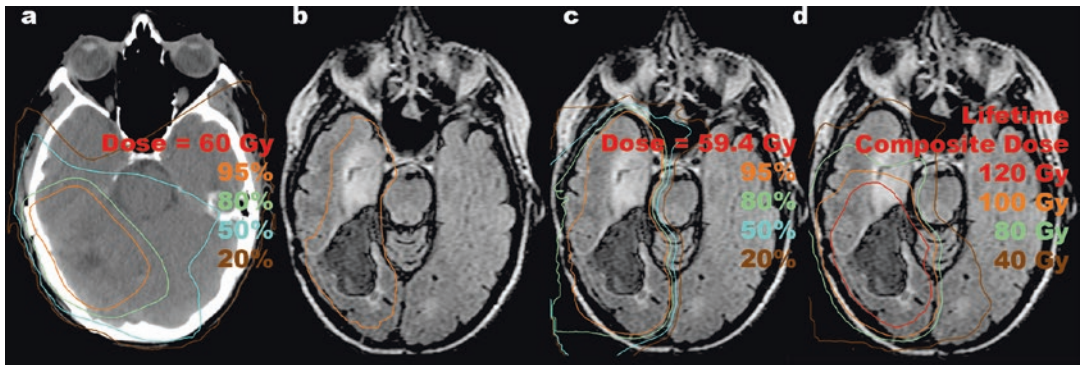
A 48-year-old woman was reirradiated for a recurrent glioma. She had a history of a complete resection of right posterior temporal anaplastic astrocytoma (grade III) and received adjuvant radiation therapy to 60 Gy in 30 fractions (a) without chemotherapy. Seven years later she developed episodes of confusion prompting MRI scan that revealed local recurrence of non-enhancing tumor with progression of FLAIR abnormality into the anterior ipsilateral temporal lobe highly suspicious for tumor. She underwent radical subtotal resection guided by functional MRI, confirming recurrent grade III astrocytoma, IDH-1 intact, with residual inoperable tumor. She was offered reirradiation with proton therapy to 59.4 Gy (RBE) in 33 fractions with concurrent temozolomide. The residual
